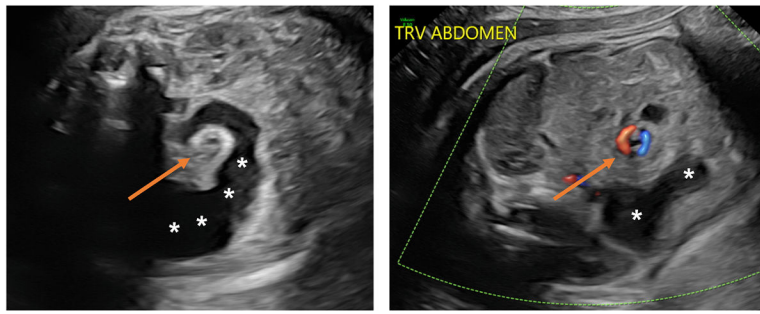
Ultrasound images at 33 weeks, 4 days demonstrate dilation of the 2nd and 3rd portions of the duodenum (asterisks), abruptly tapering as they swirl around the superior mesenteric vascular pedicle (arrows).
